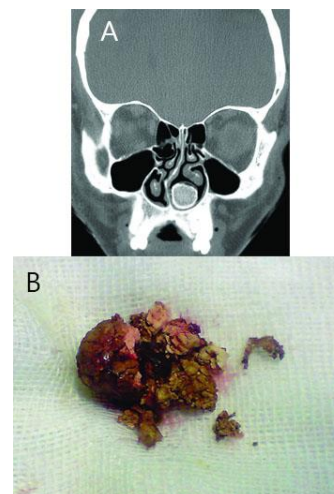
(A) Coronal computed tomography shows the rhinolith in the floor of the left nasal cavity in conjunction with septal deviation and inferior turbinate upward displacement. (B) The large foreign body that looks like an eraser piece
